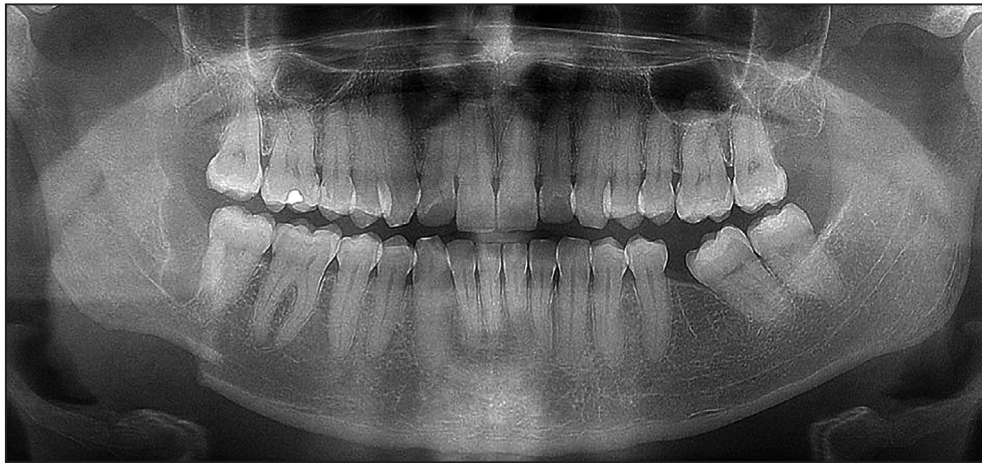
Postoperative panoramic radiograph revealing the late mandibular fracture on the right side.
